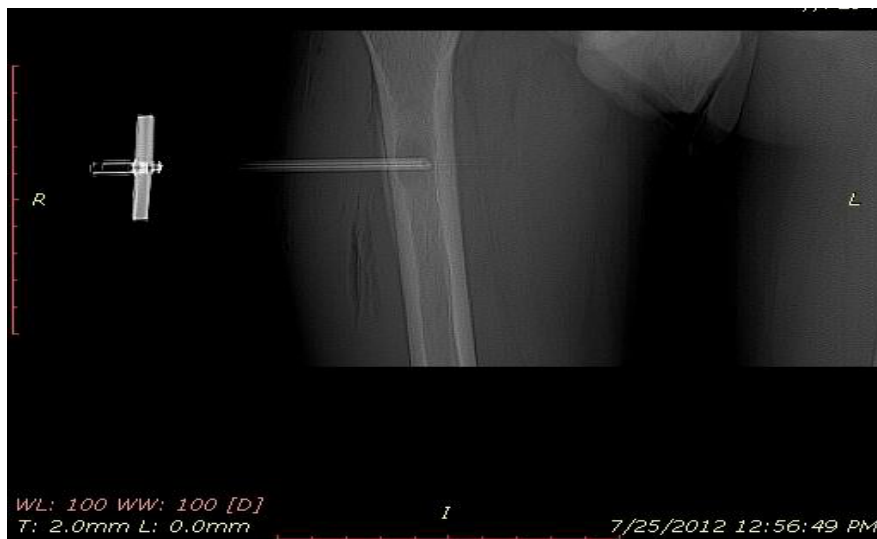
CT picture showing the trephine needle in situ.
